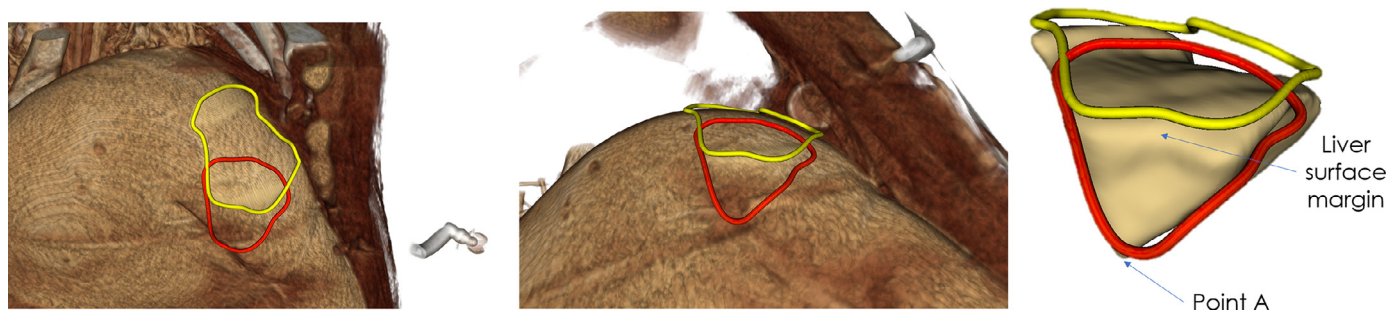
Case 4. Planned resection (yellow line) and Marked resection (red line) are shown on the volume rendering of intraoperative CT image and on the planned resection. Point A was misunderstood as the projected surface resection plane, whereas it represented the depth of the resection margin underneath the lesion within the liver parenchyma. Due to this perception error, the result from Case 4 is an outlier to the rest of the cases for the margin evaluation. This error demonstrates the need to improve the AR visualization for resection margin delineation in this surgical navigation solution. (For interpretation of the references to colour in this figure legend, the reader is referred to the web version of this article.)
